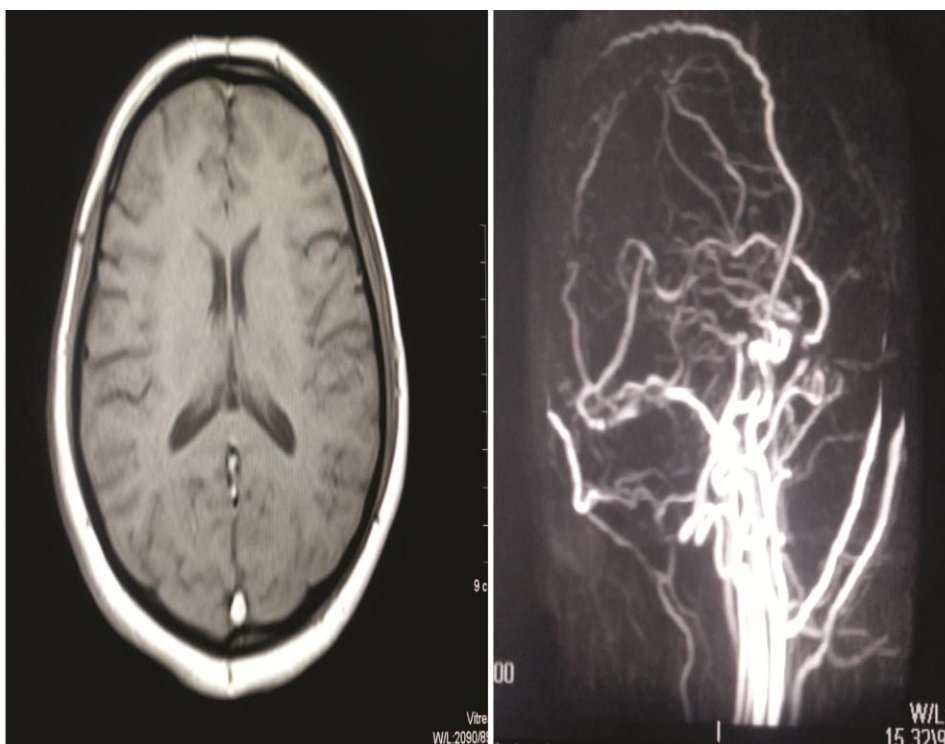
MRI T1 image shows loss of signal void in sigmoid sinus and cerebral venous thrombus on MRV.
